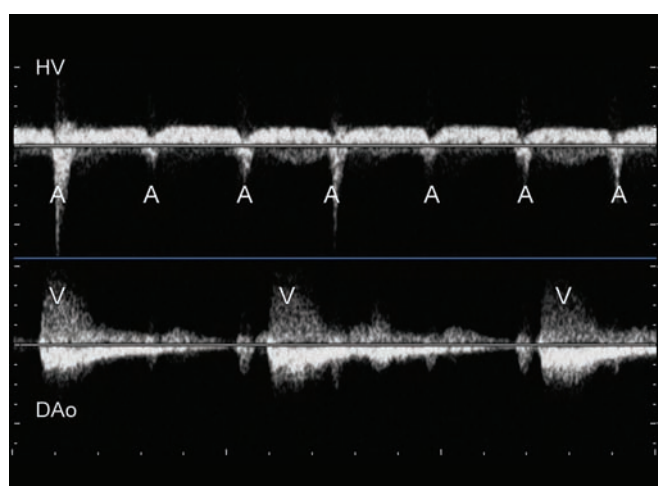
Dual Doppler recordings of the HV and DAo from a fetus with complete AVB. There is lack of atrioventricular synchrony with an atrial rate of 136 bpm and ventricular rate of 58 bpm
